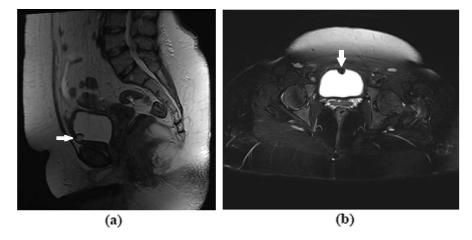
(a) Sagittal T2-weighted images showing the high-signal mass lesion in the anterior of the bladder, (b) Axial fat-suppressed T2-weighted images showing the suppression of the signal.
